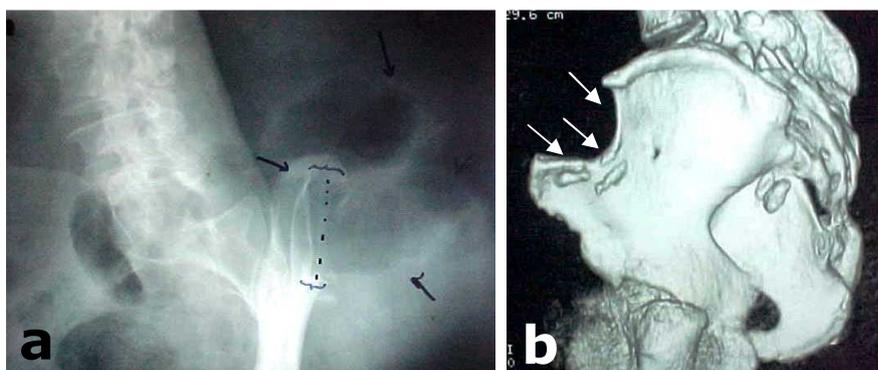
a) Plain radiograph of pelvis confirming defect in iliac crest (Brackets with broken line) and bowel in hernial sac (arrows), and b) a reconstructed CT image of the pelvis showing the defect in left iliac crest (arrows).
